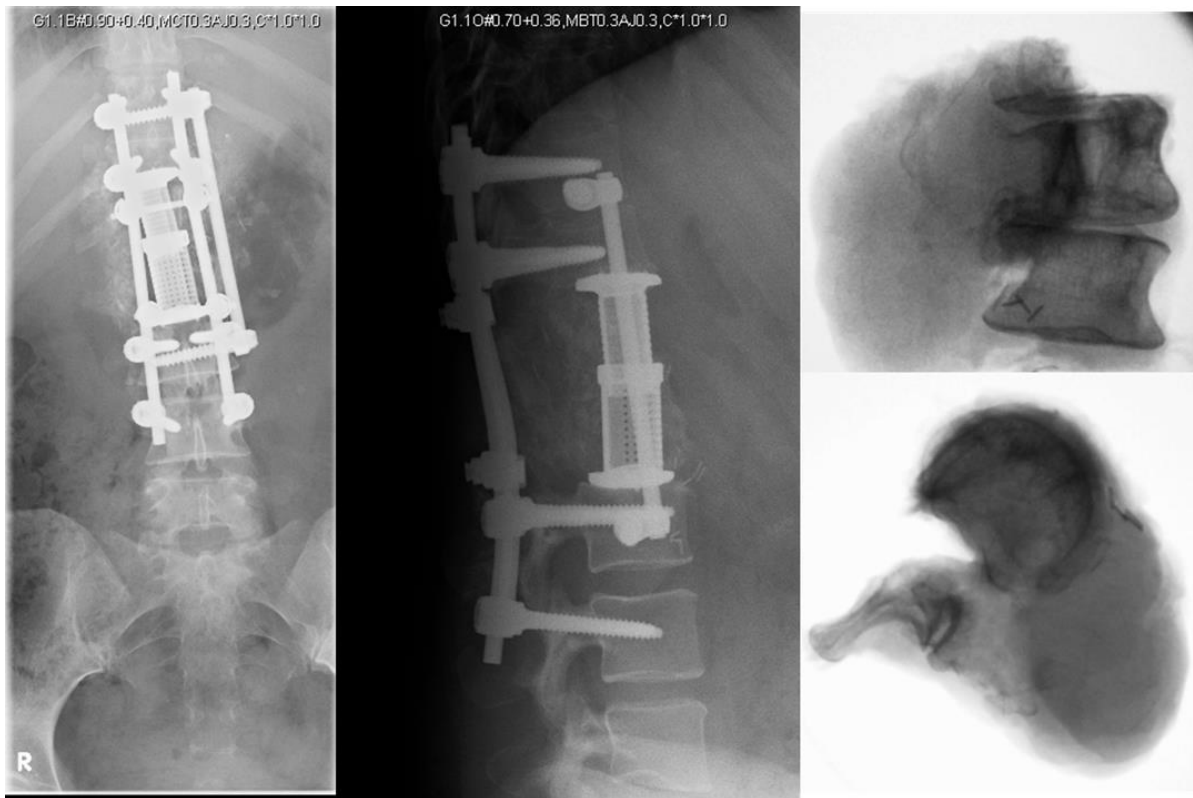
Post-operative patient radiographs, and post-operative radiographs of the excised tumour
